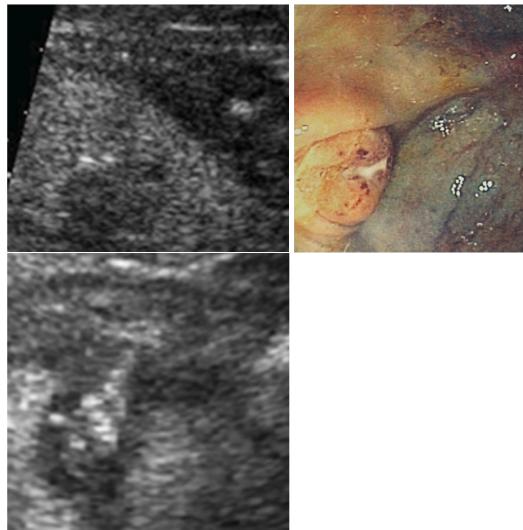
a-c Acute purulent diverticulitis with covered perforation (clinical acute abdomen); LAS longitudinal and transverse (sonographic picture (a, c) with abscess and gaseous trail in b)
